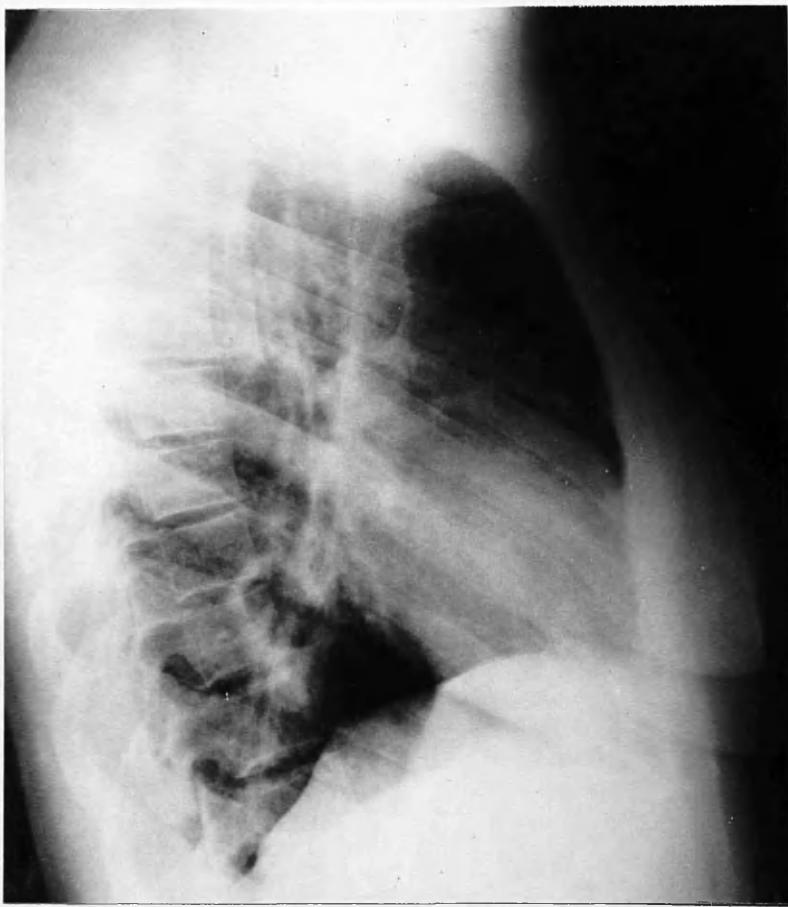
Right lateral radiograph taken on 10.11.52. There is a large cavity in the lateral basal segment of the right lower lobe.
